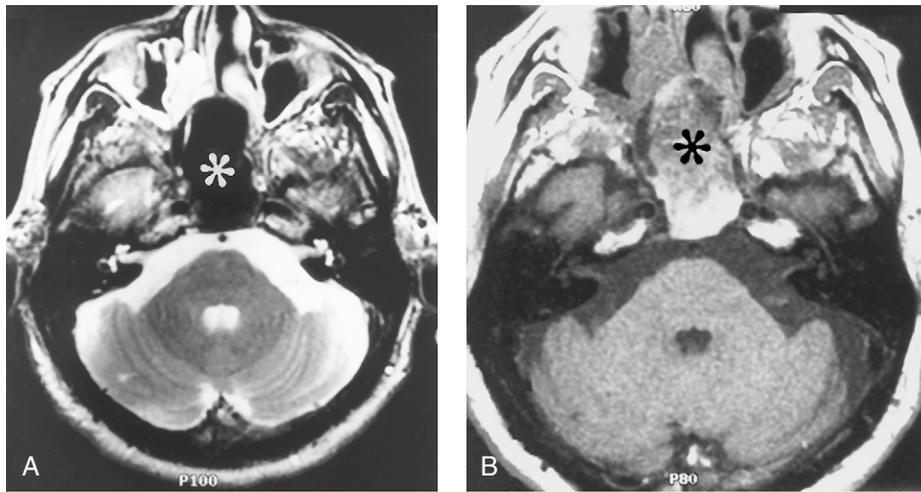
Aspergillus* sphenoid sinusitis. (A) Axial T2-weighted image through the maxillary and sphenoid sinuses shows marked hypointensity (white asterisk) in the sphenoid sinus which mimics normal aeration. (B) Axial T1-weighted image at the same level demonstrates that the sphenoid sinus is full of soft tissue (black asterisk) and is not normally aerated.
